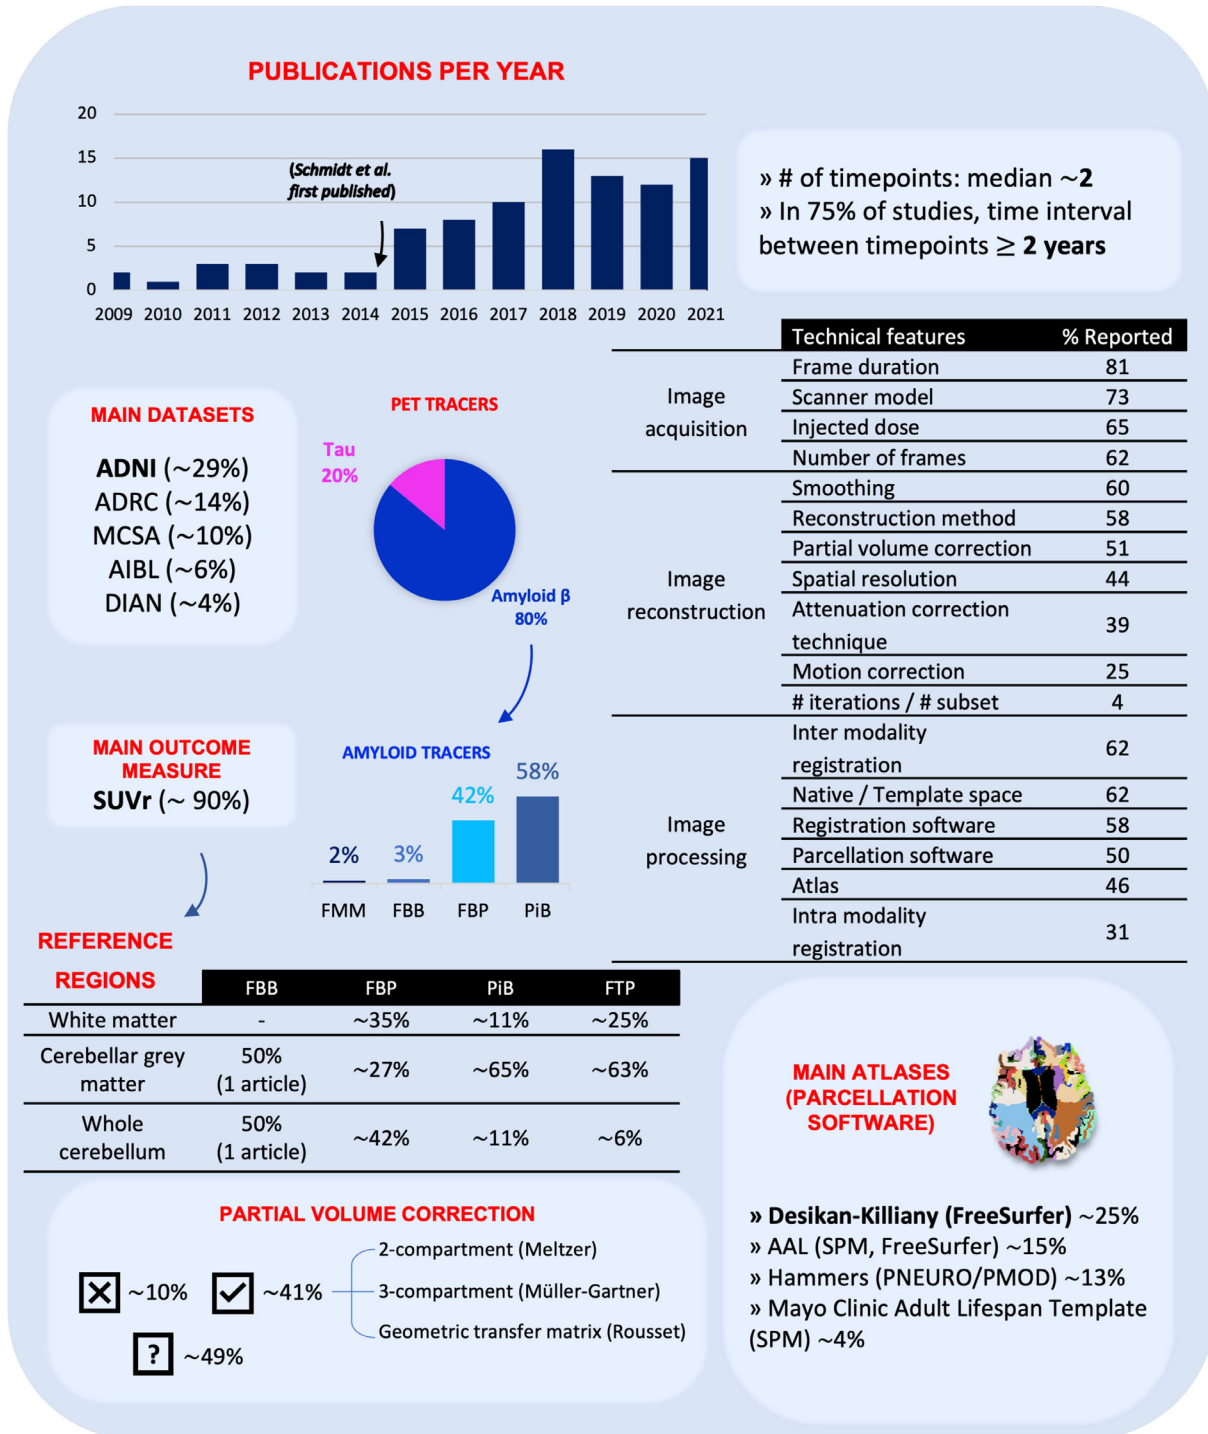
Overview of the literature published in peer-reviewed journals relating the use of longitudinal amyloid or tau positron emission tomography (PET) studies. Percentages represent the number of studies that report using a specific feature (radiotracer, reference region, and so on). Because some studies used multiple tracers or compared different reference regions, these percentages may not add up to 100%. ADNI: Alzheimer's Disease Neuroimaging Initiative; ADRC: Alzheimer's Disease Research Center; DIAN: Dominantly Inherited Alzheimer Network; MCSA: Mayo Clinic Study of Aging; SUVr: standard uptake value ratio; SPM: statistical parametric mapping; AAL: automated anatomic labeling; FMM: ¹⁸F-flutemetamol; FBB: ¹⁸F-florbetaben; FBP: ¹⁸F-florbetapir; PiB: ¹¹C-PiB; FTP: ¹⁸F-flortaucipir.
